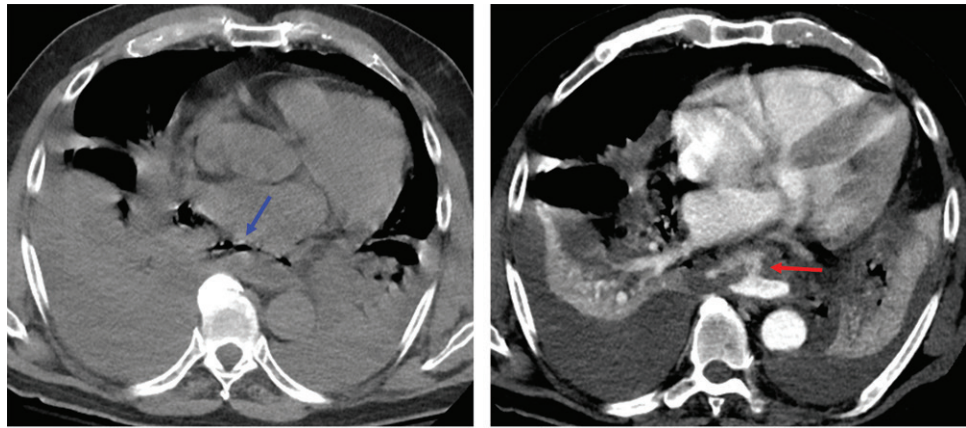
Leak at the gastroesophageal junction in a patient with acute-onset epigastric pain. (a) Axial CT esophagogram shows pneumomediastinum and paraesophageal air (arrow) that were identified at non-enhanced abdominal CT (not shown). (b) Axial postcontrast CT esophagogram shows a leak at the posterior gastroesophageal junction (arrow).
